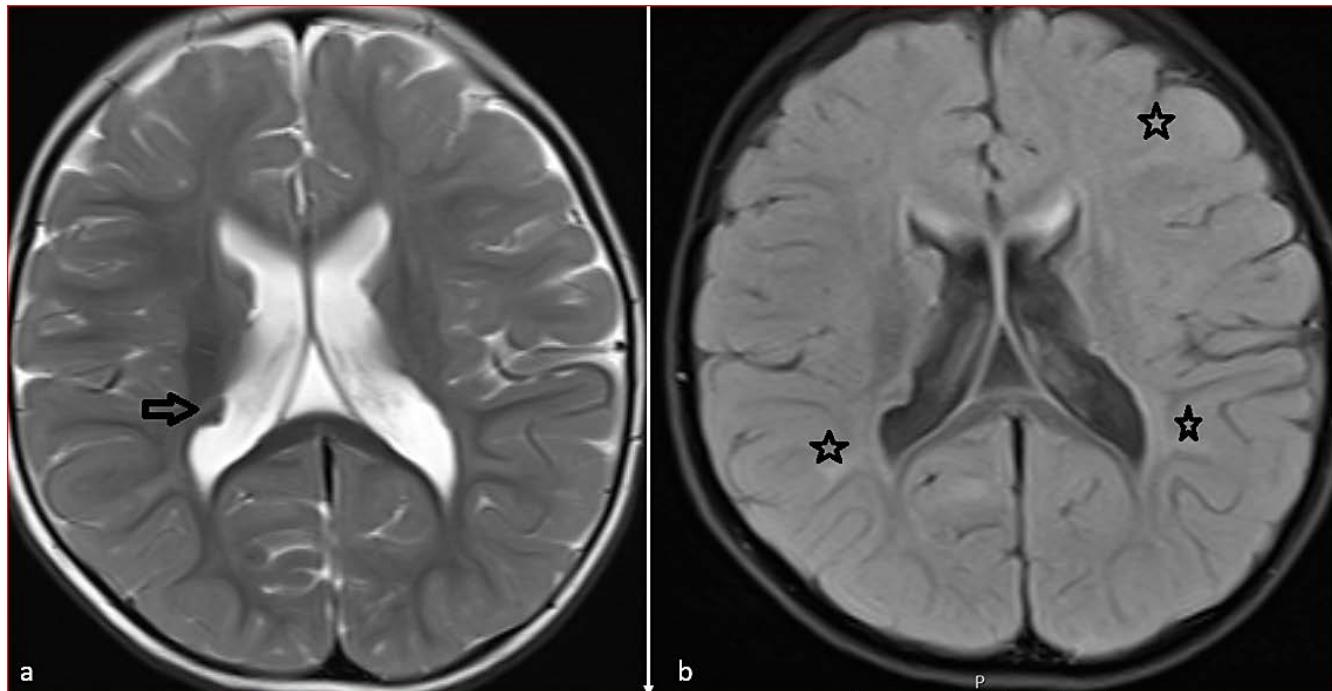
Brain MRI images of a 2-year-old male patient diagnosed with tuberous sclerosis. On T2W axial image, isointense nodular appearance compatible with subependymal nodule on the right lateral ventricular wall is remarkable arrow . On T2 FLAIR W axial image, patchy hyperintense areas consistent with hamartoma in the subcortical areas of bilateral cerebral hemispheres are noted (*).
